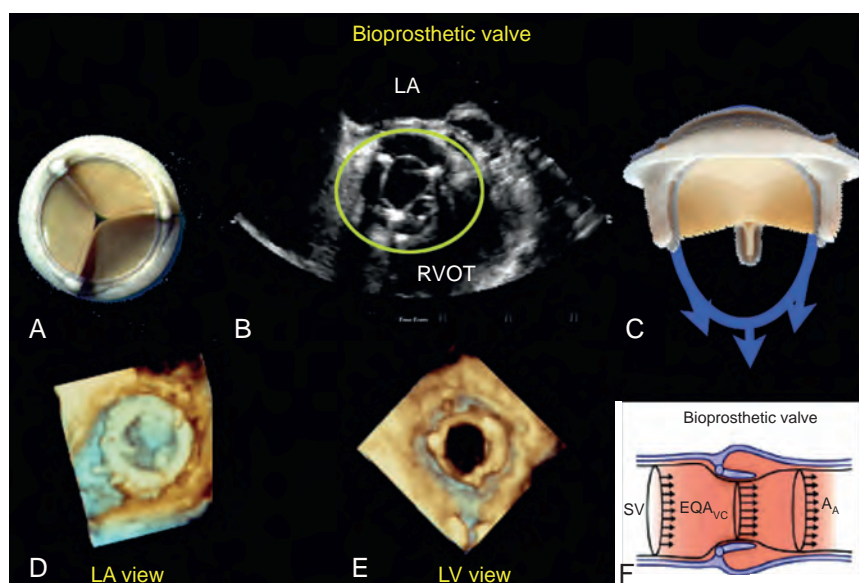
Flows across bioprosthetic valves. The figure highlights the appearance and flow across a bioprosthetic valve. The valve is shown in the mitral and aortic positions. (A) and (B) Valve in short-axis view looking from downstream. (C) View highlighting the main single forward flow pattern. (D) and (E) Three-dimensional echocardiographic views of the mitral position from the left atrial (LA) perspective during systole and the left ventricular (LV) perspective during diastole. (F) Another view highlighting the main single forward flow pattern. A_A, Ascending aorta; EQA_{VC}, estimated qualitative area vena contracta; RVOT, right ventricular outflow tract; SV, stroke volume.
